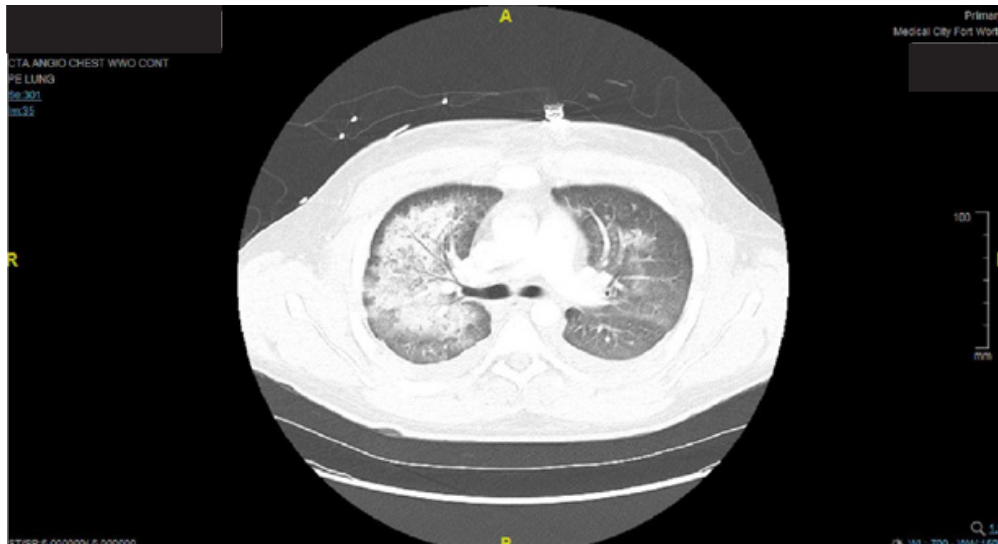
Computed tomography angiography showing bilateral ground glass opacities with smooth interlobular septal thickening.
